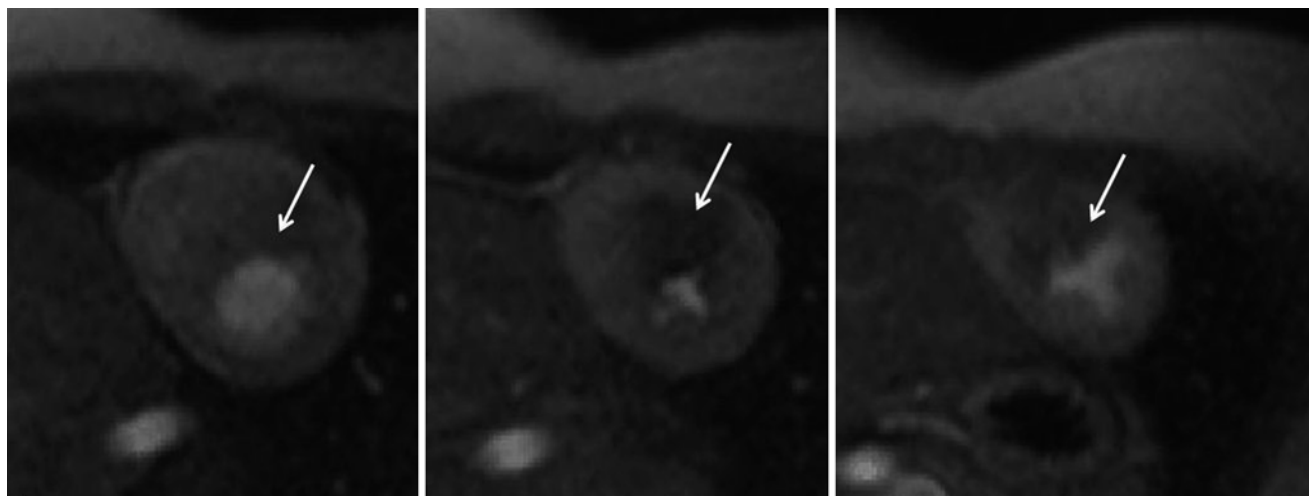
Stress adenosine MRI showing basal to apical short axis views with perfusion defects (*arrows*) in the mid hypertrophied septum demonstrating microvascular ischemia
